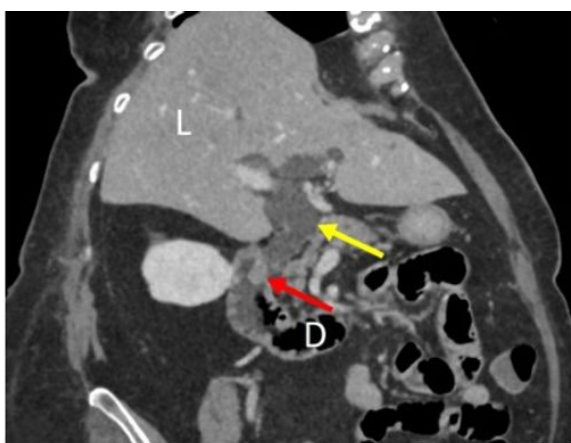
Coronal oblique reconstruction of contrast enhanced abdominal computed tomography scan of 89-year-old female patient shows significantly dilated common bile duct (yellow arrow). The major duodenal papilla had a nodular aspect (red arrow), and an ampullary tumor was included in the differential diagnosis. L = liver; D = duodenum.
